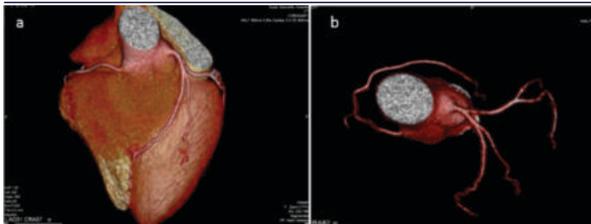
and 1 b. 3D volume rendered images of CT angiography of coronary arteries depicting normal anatomy.
